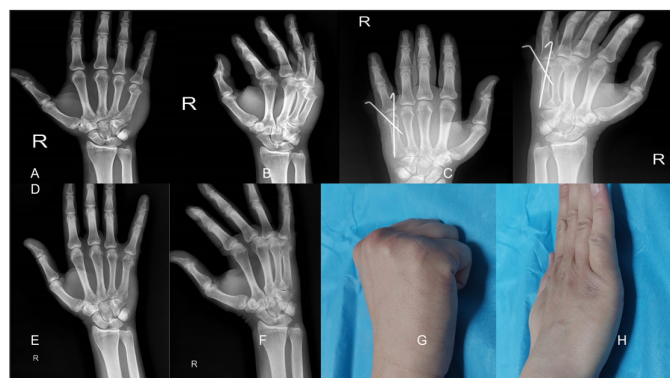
35 years male patient treated with retrograde crossed pinning. Preoperative AP view radiograph (A). Preoperative oblique view radiograph (B). Postoperative radiographs showing a good reduction of the fracture on the anteroposterior view (C) and oblique view (D). Radiograph in the 6th month after the removal of the nails on the anteroposterior view (E) and oblique view (F). ROM of the MCP in flexion (G) and extension (H) in the final follow-up.
